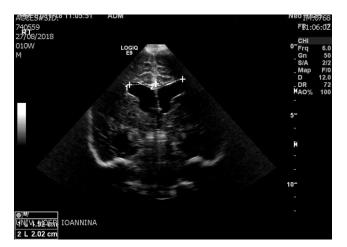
Ultrasound at 35 weeks of gestation demonstrating no signs of ventriculomegaly.
